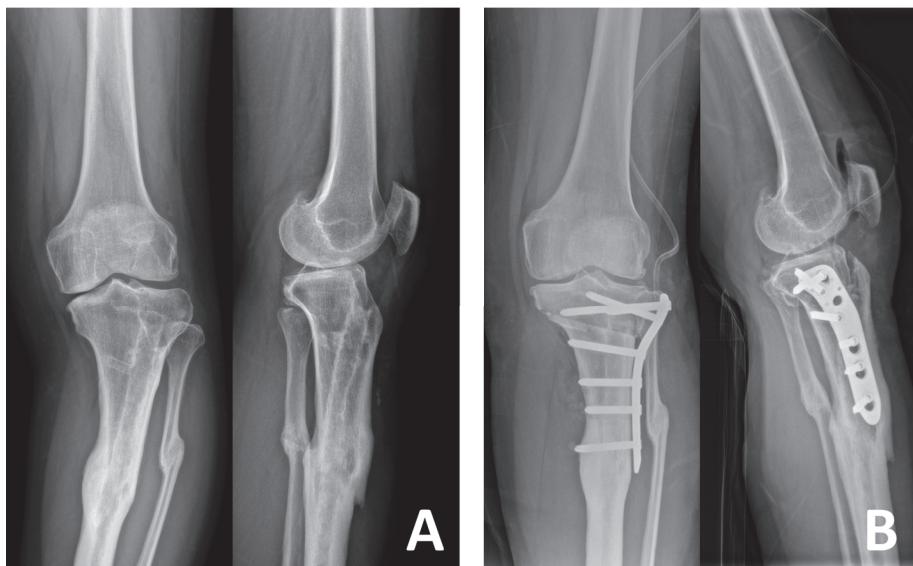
Preoperative (A) and postoperative (B) radiographs of a 42-year-old female patient who underwent LCWHTO using the TSO technique. LCWHTO: lateral close-wedge high tibial osteotomy; TSO: tibial-sided osteotomy.
